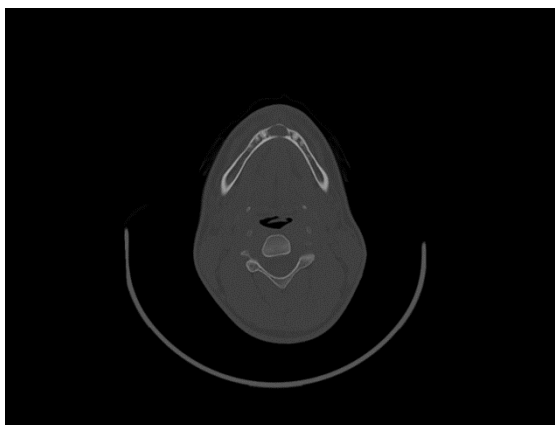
Well-defined hypodense area in the mandibular symphysis observed on axial view of CT.
